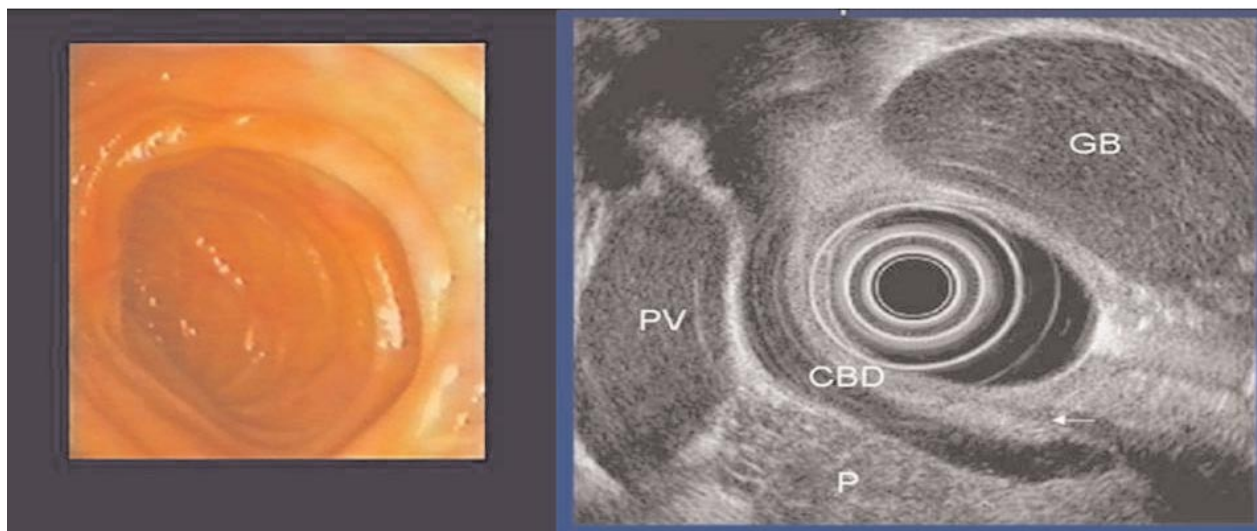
Endoscopic and ultrasonographic images of the duodenum. CBD = common bile duct, PV = portal vein, GB = gall bladder, P = pancreas.
